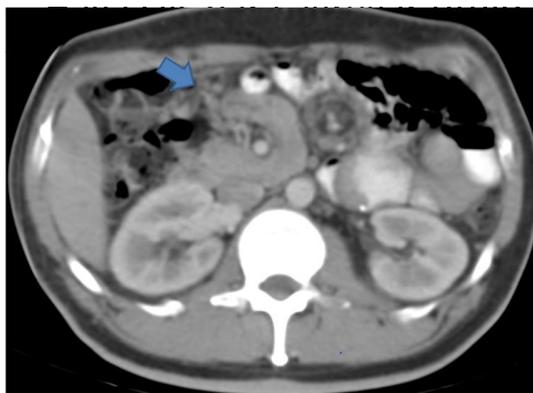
Abdominal CT with intravenous and oral contrast. Arrow: displacement to the right of the Treitz ligament.
